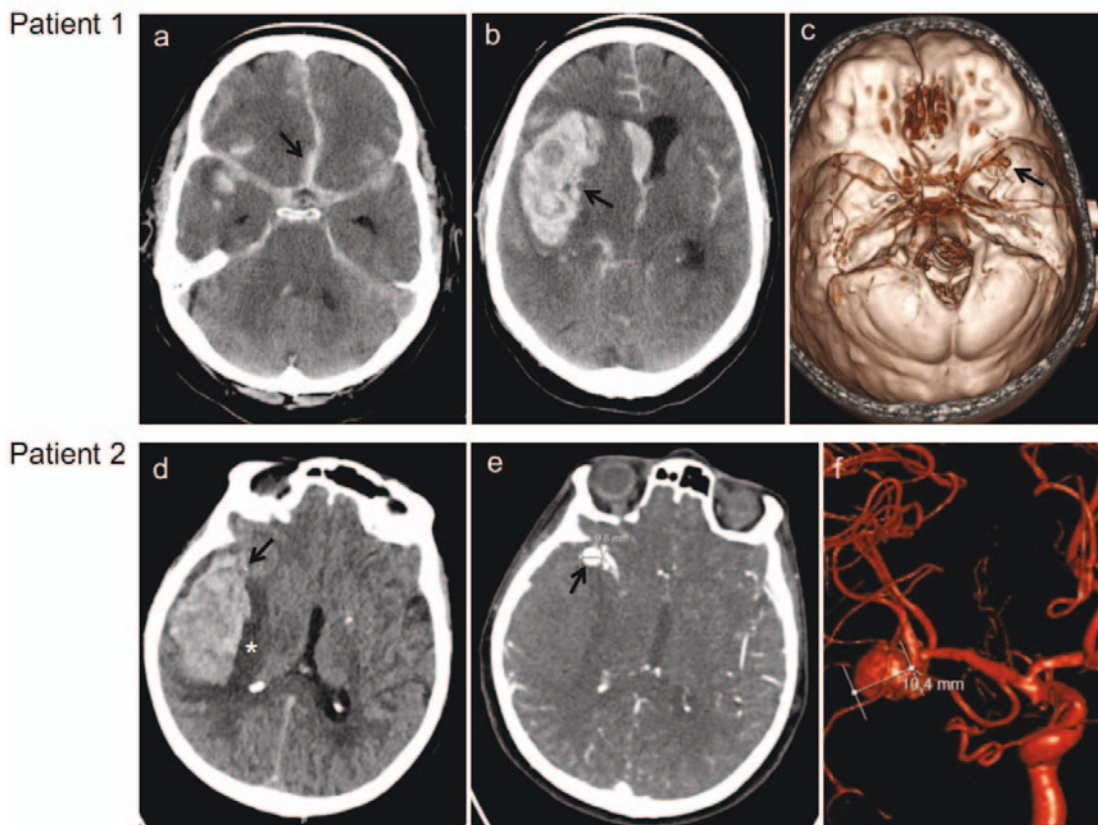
Computed tomography (CT) images of two patients with ruptured middle cerebral artery (MCA) bifurcation IAs. a Patient 1: subarachnoid hemorrhage (SAH, white, arrow) and b intracerebral hemorrhage (ICH, white, arrow), c CT-angiography (CTA) reconstruction, same patient, showing the aneurysm (arrow) in MCA. Patient 2: d ICH (arrow) is surrounded by edema (star). e shows the IA in CT-angiography CTA and f in 3D digital subtraction angiography (DSA) images. (Images from Dr. Juhana Frösen, Department of Neurosurgery, Kuopio University Hospital, Kuopio, Finland.
